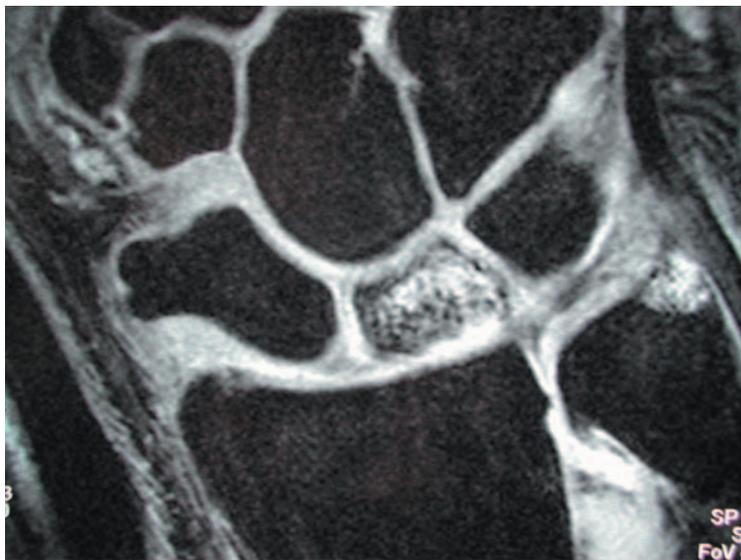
T2 weighted MRI of the wrist showing markedly increased signal within the lunate suggestive of Kienböck's disease.
